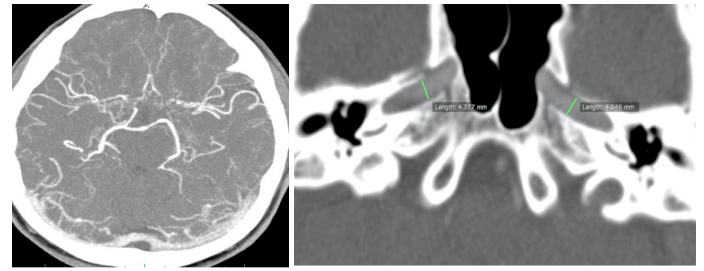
48-year-old woman with Moyamoya disease. Axial maximum intensity projection CT image of Moyamoya case (a) showing increased leptomeningeal vascularization secondary to anterior cerebral artery occlusion seen bilaterally. Axial CT image (b) shows bilaterally smaller carotid canals.
